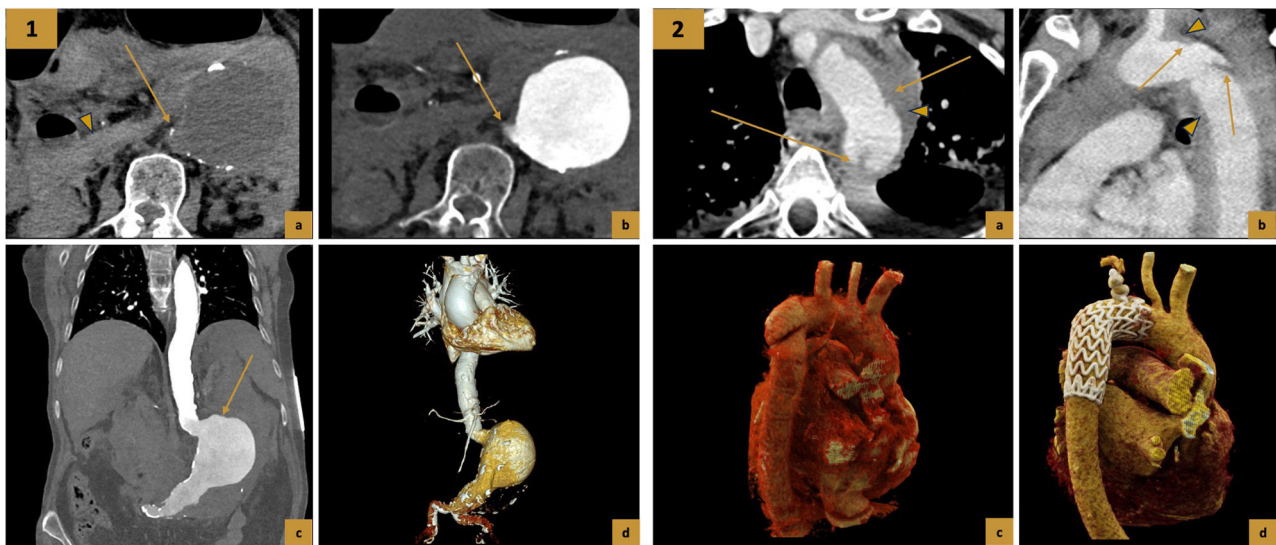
1. Ruptured abdominal aortic aneurysm. (a, b, c, and d) Non-contrast CT, axial slice, contrast-enhanced CT in the arterial phase, axial and sagittal slices, and 3D volumetric reconstruction respectively. Large aneurysmal sac with peripheral intimal calcifications, extensive haemoretroperitoneum (arrowhead), and alteration of the contour of the aneurysmal sac wall at its right lateral margin (arrows). 2. Aortic pseudoaneurysm in the isthmus resulting from high-impact chest trauma in a road traffic accident. (a and b) Contrast-enhanced CT scan in the portal phase, axial and oblique sagittal slices. Flap (arrows) at the isthmus with pseudoaneurysm formation, periaortic haematoma (arrowheads), and associated haemothorax. (c) 3D reconstruction, posterior view, pseudoaneurysm in the isthmus, immediately distal to the subclavian artery exit. (d) 3D reconstruction, posterior view, result after aortic endograft implantation, excluding the chimney aneurysm in the left subclavian artery due to the short distance from the neck when fixing the prosthesis to its proximal segment.
